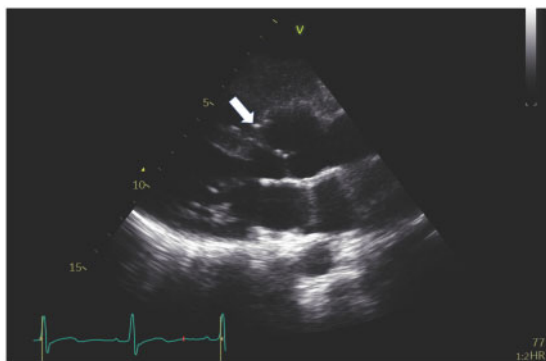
Postoperative transthoracic echocardiography long-axis parasternal view showing the repair site.
